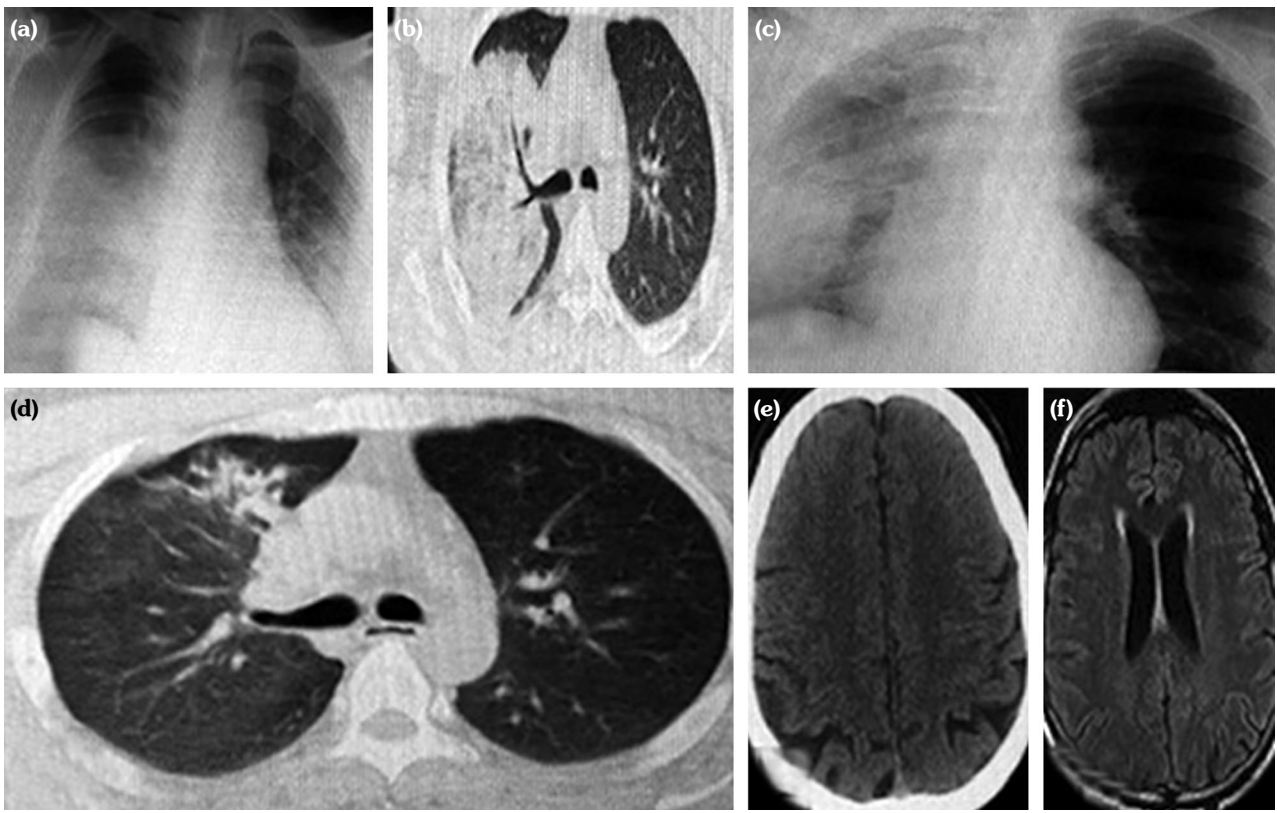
(a-d) Ground glass opacities on X-ray and thorax computed tomography. (e, f) Normal magnetic resonance imaging of the patient's brain.
